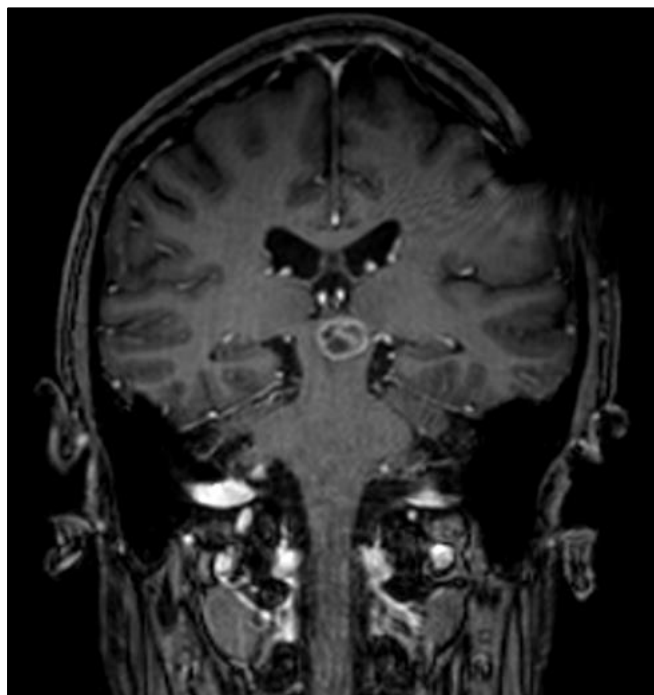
MRI Coronal T1W Post Contrast View Post Treatment after 3 Months Shows a Decrease in Thickness of the Rim and Mild Decrease in Size and Absence of Nodularity Seen before.
